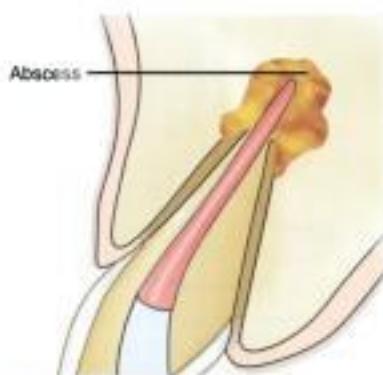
Overfilling of root canal resulting in non healing of periapical abscess
